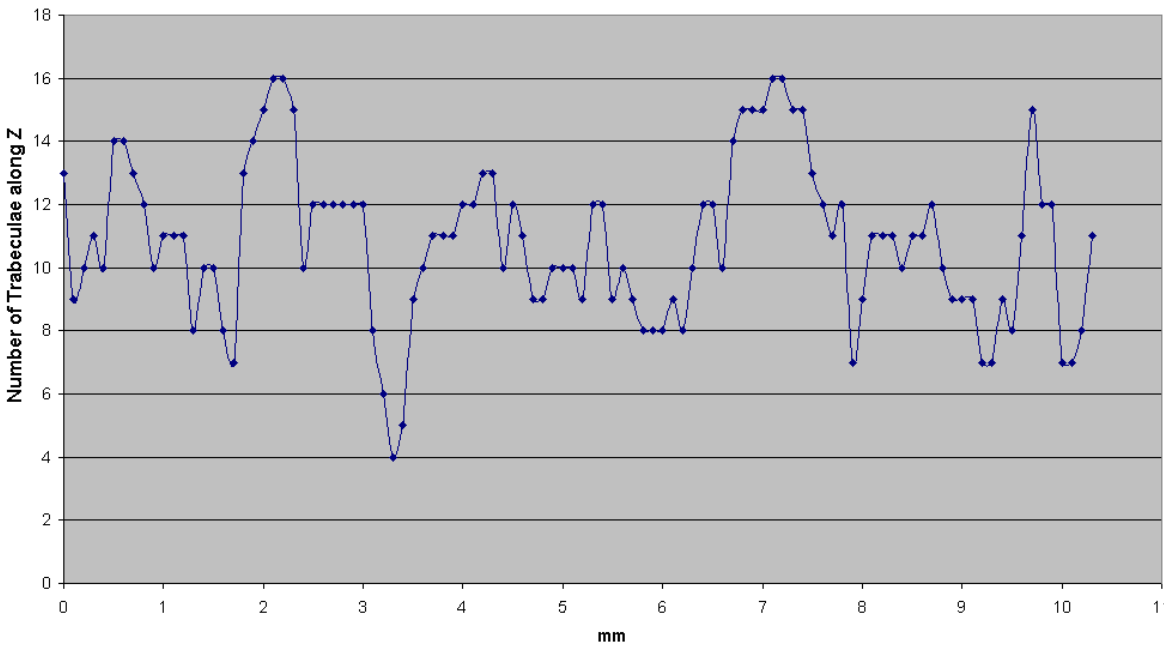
Cubic  $\mu$ CT sample: number of trabeculae along Z
